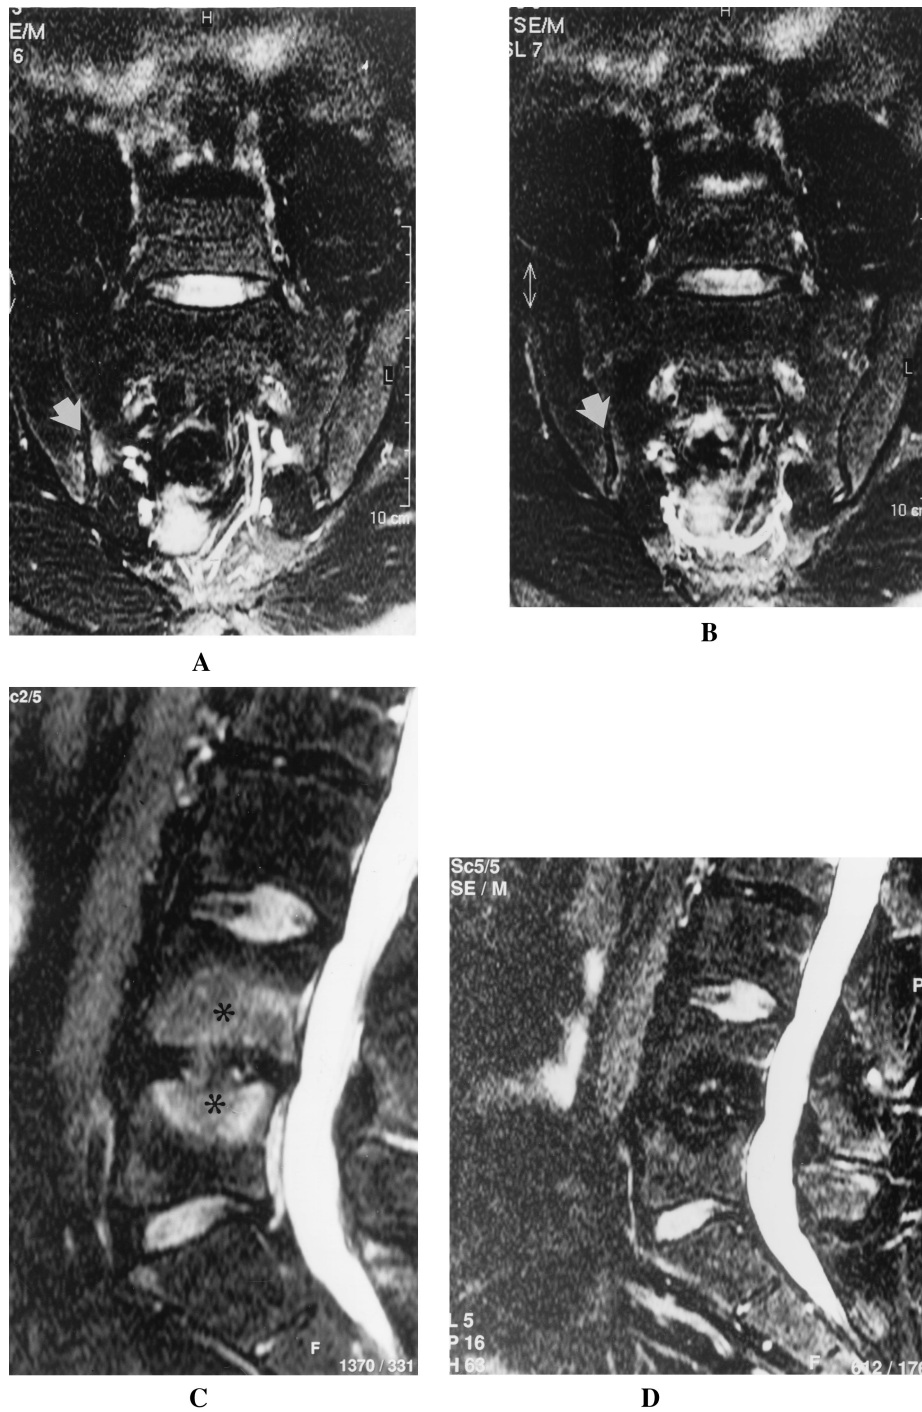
T2-weighted fat-suppressed (FS) coronal oblique magnetic resonance image of the sacroiliac (SI) joints of a patient with undifferentiated spondylarthropathy A, before, and B, after treatment with etanercept, showing resolution of bone edema in the inferior aspect of the right SI joint (white arrows). C, T2-weighted FS sagittal sequence of the lumbar spine of a patient with Crohn's-related spondylitis showing end-plate edema of the L4 inferior and L5 superior vertebral bodies (black asterisks). D, Followup scan after treatment with etanercept shows complete resolution of the edema.
